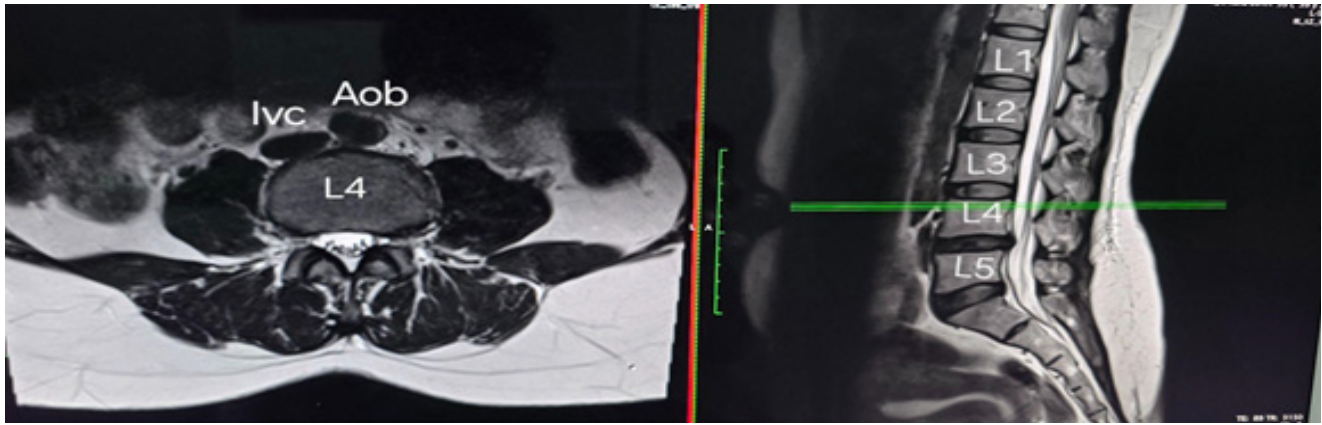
Axial and sagittal MRI of Lumbosacral spine , aortic bifurcation at the level of upper border of L4 vertebra. Aob: aortic bifurcation, Ivc: Inferior venecava, L1,L2,L3,L4 and L5 : Lumbar vertebral bodies.
